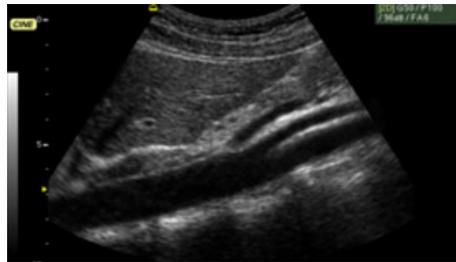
Ultrasound image of the abdominal aorta (Abdominal Aorta)
